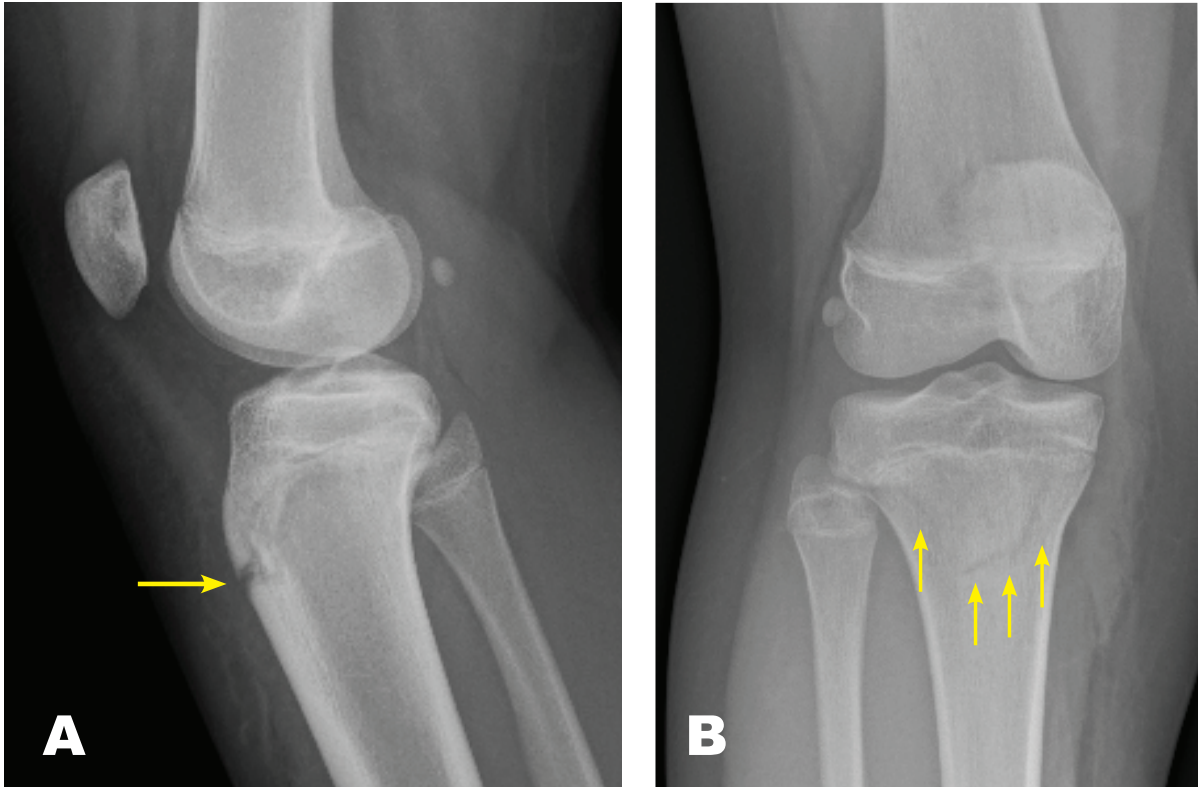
Lateral (A) and anteroposterior (B) radiographs of the right knee showing a fracture (arrows) of the tibial tuberosity extending to the tibial condyles. Images were obtained on the day of the fracture occurrence.
